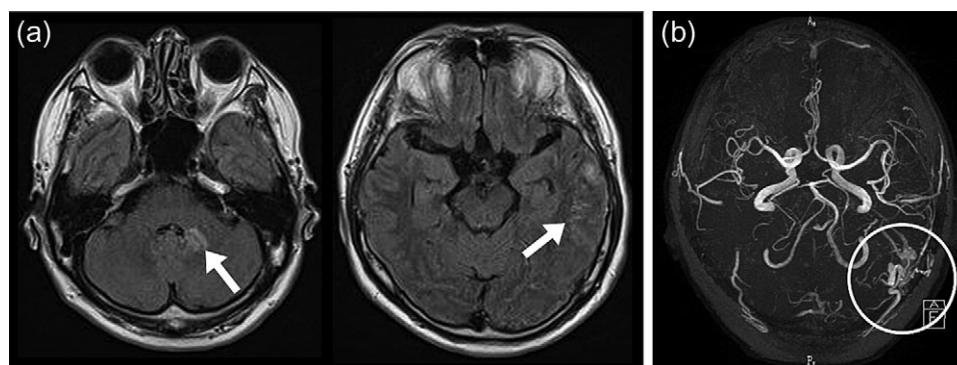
(a) Image obtained with fluid-attenuated inversion recovery magnetic resonance imaging of the head. A high intensity region was found in the left cerebellar dentate nucleus and the left parietal cortex (white arrows). (b) Head magnetic resonance angiography. An abnormal blood vessel was found intersecting from the left middle meningeal artery and the left occipital artery to the left transverse-sigmoid sinus (white circles). This was considered to be a left transverse-sigmoid sinus dural arteriovenous fistula.
